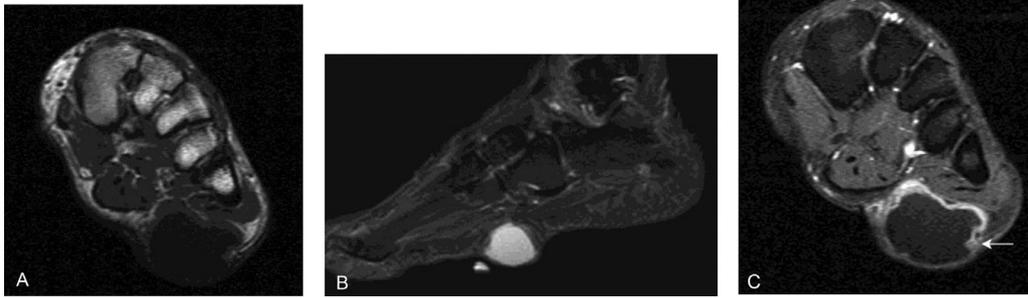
Clear cell hidradenoma. (A) Coronal short-axis T1WI shows a lobulated mass in the plantar aspect of the foot. (B) On sagittal fat saturated T2WI, the mass is hyperintense. (C) Coronal short-axis postcontrast fat saturated T1WI shows thick rim enhancement with nodular portions (white arrow). T1WI, T1-weighted images; T2WI, T2-weighted images.
